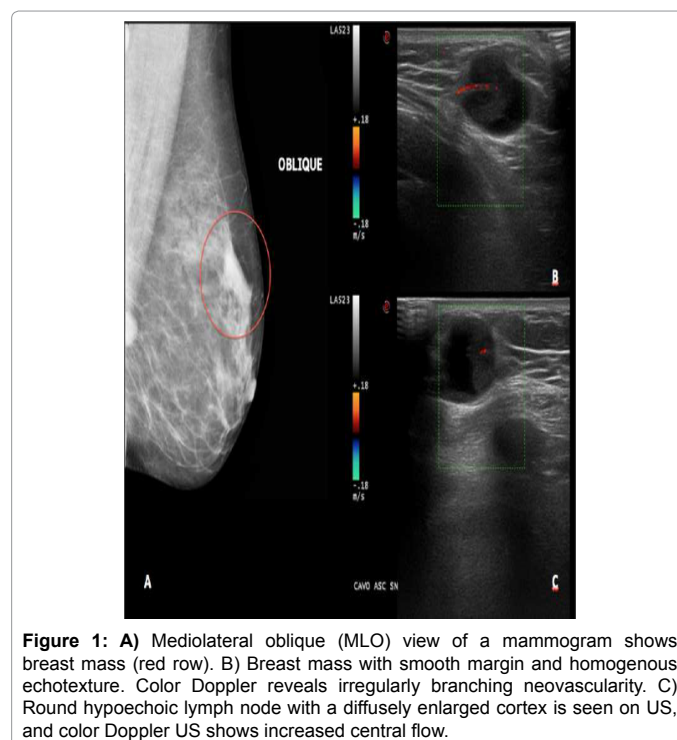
A) Mediolateral oblique (MLO) view of a mammogram shows breast mass (red row). B) Breast mass with smooth margin and homogenous echotexture. Color Doppler reveals irregularly branching neovascularity. C) Round hypoechoic lymph node with a diffusely enlarged cortex is seen on US, and color Doppler US shows increased central flow.
